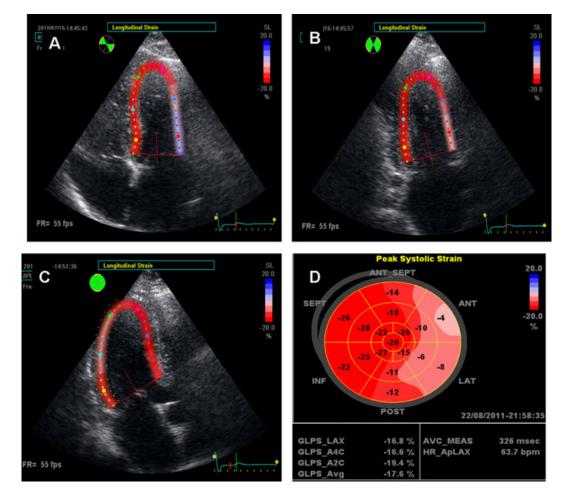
Apical four-chamber view A., apical two-chamber view B., apical three-chamber view C., and a bull's-eye rendering D. of myocardial strain in a patient with Fabry disease with left ventricular hypertrophy (LVH). The bull's-eye shows an average longitudinal peak systolic strain (GLPS_Avg) of -17.6%. Normal strain is depicted in red and the decrease in strain (values lower than -15%) is depicted in pink.
